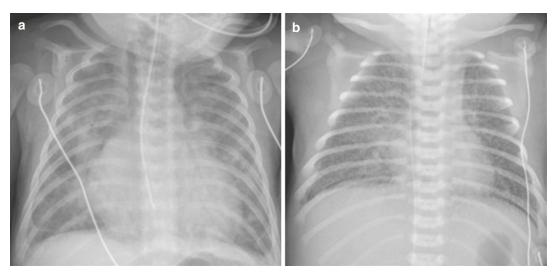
Increased vascular flow. (a) Neonate with a ventricular septal defect. Chest radiograph shows cardiomegaly and increased vascular flow. Note that the tip of the nasogastric tube (NGT) is malpositioned in the distal esophagus. (b) Chest radiograph in a neonate with total anomalous pulmonary venous return and interstitial edema. The heart is not enlarged. Bilateral pulmonary vessels are ill defined representing venous congestion. Prominent and bilateral interstitial markings are seen suggesting edema. Associated small right pleural effusion is noted
